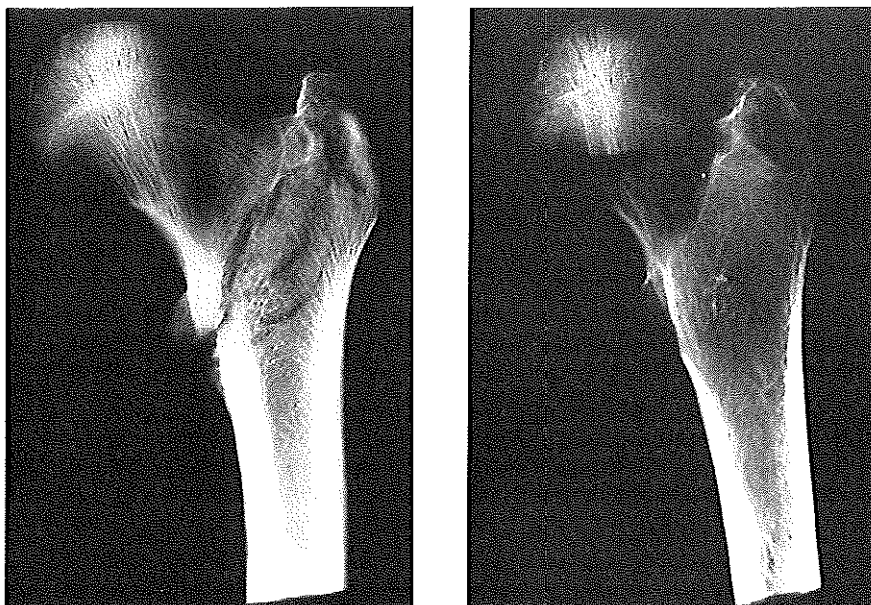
Radiographs of fractures after semi-static testing
